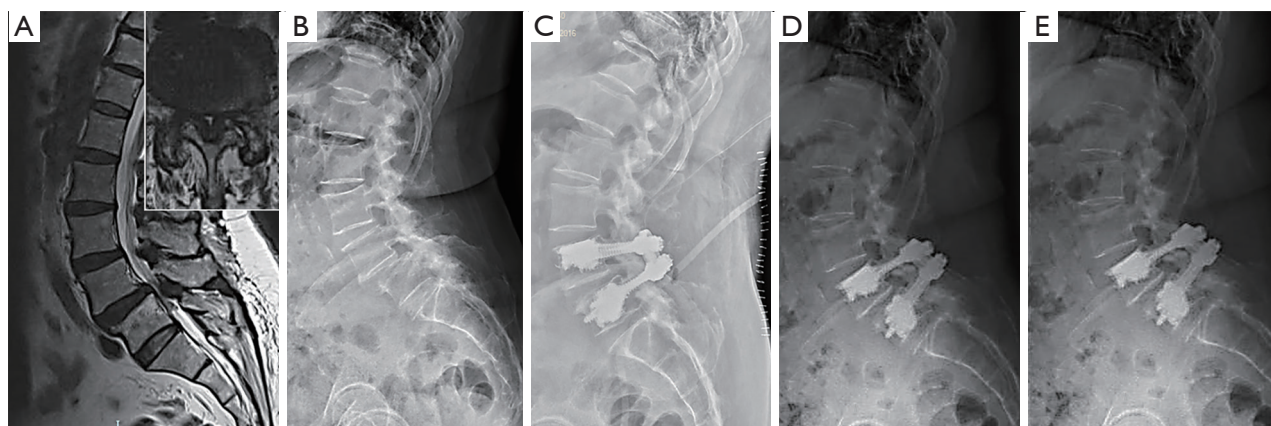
Sequential MRI and X-rays of a 78-year-old woman undergoing surgical treatment. (A,B) Preoperative MRI scan and lateral radiograph of a 78-year-old female who underwent decompression and 1-level posterolateral instrumented fusion with cemented PMMA pedicle screw augmentation; (C) immediate postoperative lateral radiograph at 24 hours; (D) postoperative lateral radiograph at 6 months showing stable reduction; (E) 4-year postoperative lateral radiograph evidencing preserved spinal alignment and implant placement. MRI, magnetic resonance imaging; PMMA, polymethylmethacrylate.
